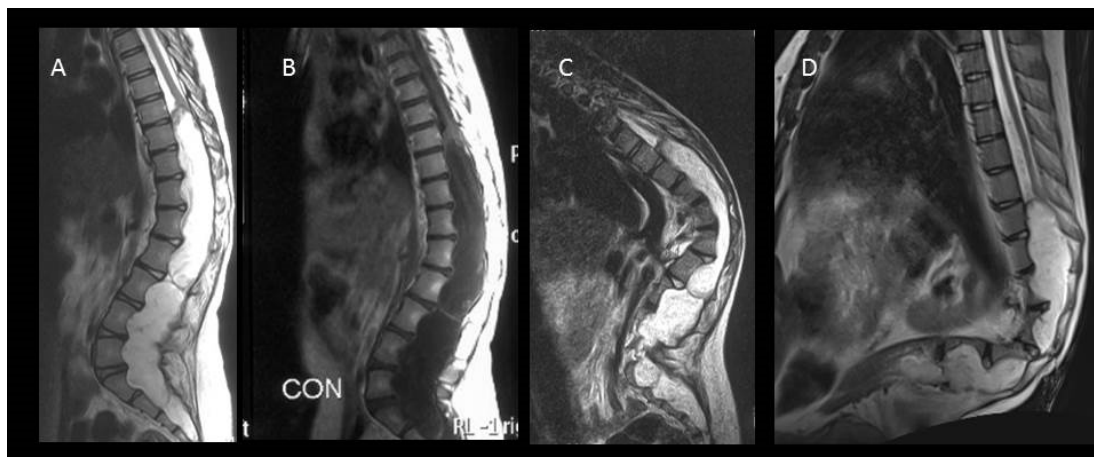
Sagittal MRI images of the spine T2W (A) T1W-post gadolinium (B) from 2014, T2W from 2016 (C), and T2W from 2018 (D). Images show a large cystic lesion occupying the lower thoracic, lumbar and sacral spinal canal with minimal enhancing septation causing increasing scalloping of the vertebral bodies and worsening kyphosis.
